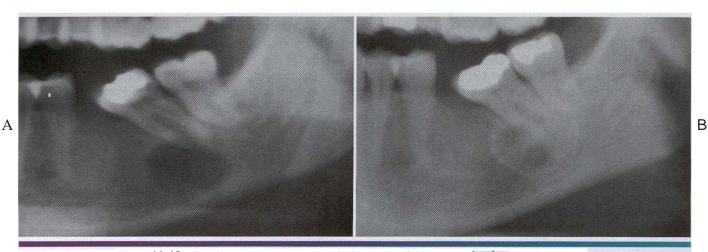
• Focal cementa-osseous dysplasia. A, A radiolucent area involves the edentulous first molar area and the apical area of the second molar. B, Radiograph of the same patient taken 9 years later showing a mixed radiolucent and radiopa que pattern.
